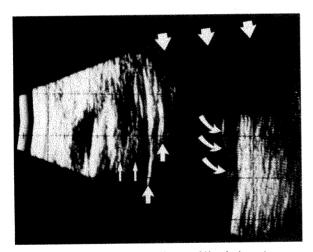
(Whitacre). A 40% gas-fill of the vitreous cavity was present in an aphakic eye after vitrectomy. The patient's head was erect and the ultrasound probe was in line with the visual axis. Medium amplitude reverberations were present behind the iris from the gas-tissue and gas-fluid interface (small straight arrows). High amplitude reverberations were produced by ultrasound echoing between the gas surface and the transducer tip (medium straight arrows). Posterior shadowing was present (large arrows) and obscured the superior portion of a retinal detachment (curved arrows).
